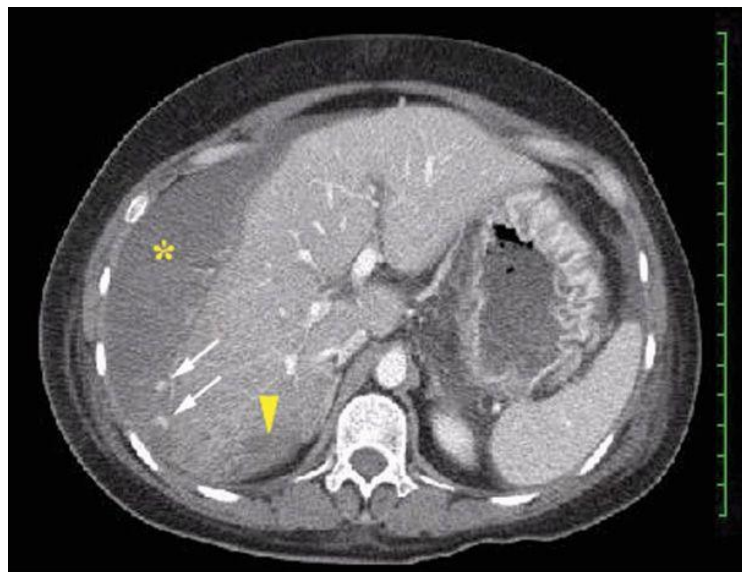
Abdominal CT imaging performed postpartum in a woman with severe HELLP syndrome and right-upper quadrant pain. A large subcapsular hematoma (asterisk) is seen confluent with intrahepatic infarction and hematoma (arrowhead). Numerous flame-shaped hemorrhages are seen at the hematoma interface (arrows).
